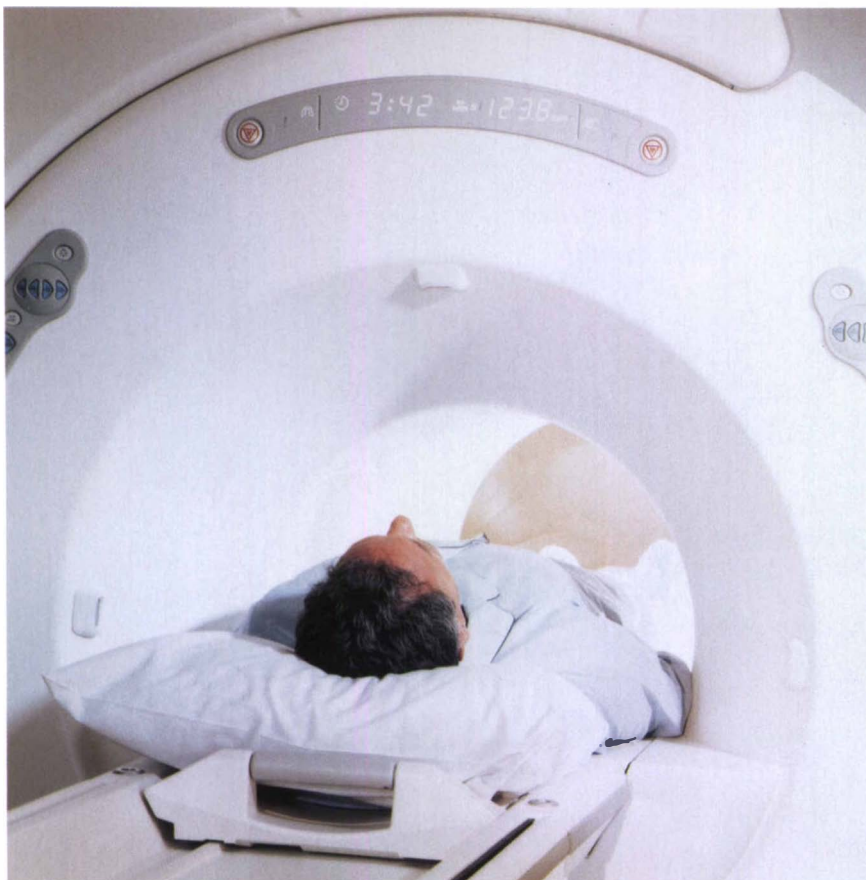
Patient prepared for MRI.
